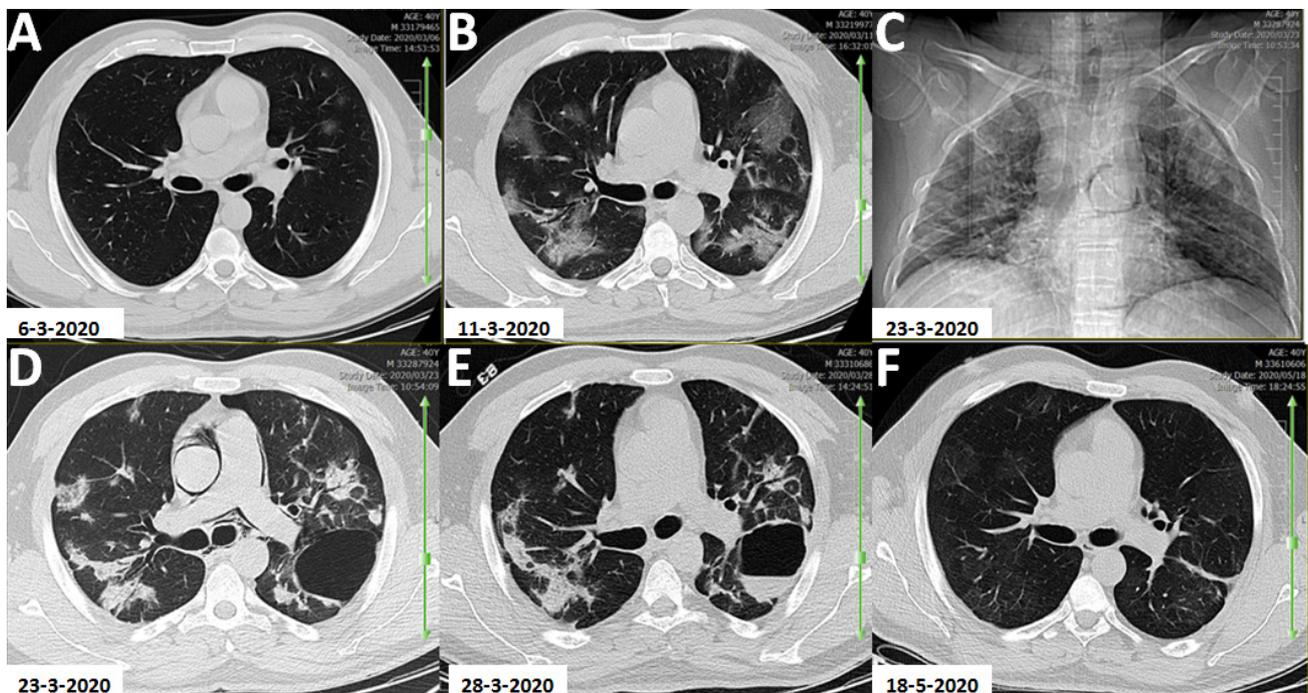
Multiple chest CT scan images without contrast showed small GGO in the left lung at admission day (A), multifocal and bilateral patchy GGO five days later (B), bilateral patchy consolidative opacities with large bulla formation in the left lung, pneumomediastinum and left pneumothorax on 17th day of hospitalization (C-D), bilateral patchy consolidative opacities with an air-fluid level in left lung bulla with complete resolving of pneumomediastinum and pneumothorax (E), and finally complete resolution of opacities and bulla with very faint residual GGO in follow up ct scan 50 days later.
